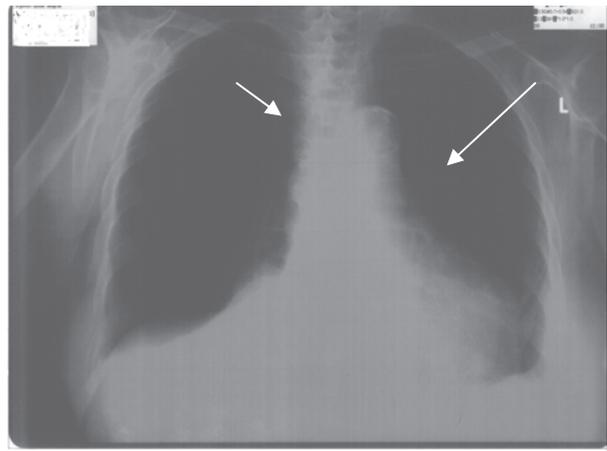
Chest radiography showing a distorted right atrial border with small bilateral pleural effusion.
